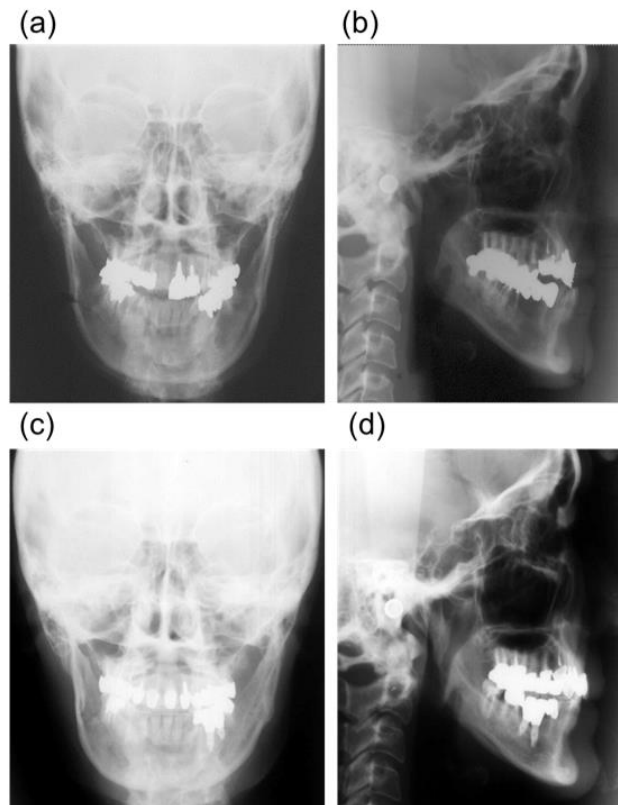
Pre- and post-treatment radiographs. A) Pre- and C) post-treatment frontal cephalograms. B) Pre- and D) post-treatment lateral cephalograms.
